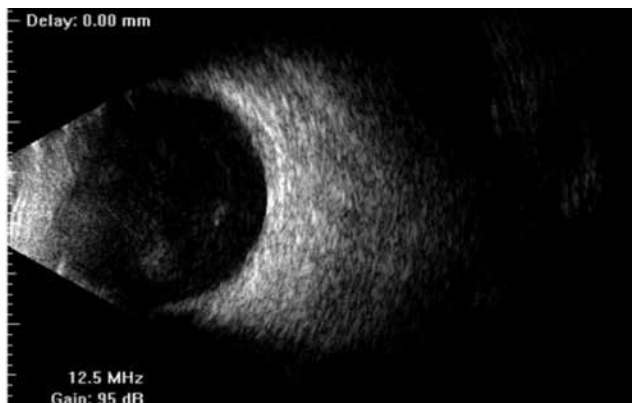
B-scan ultrasonography showing clear vitreous with no choroidal thickening and no exudative retinal detachment in the right eye
